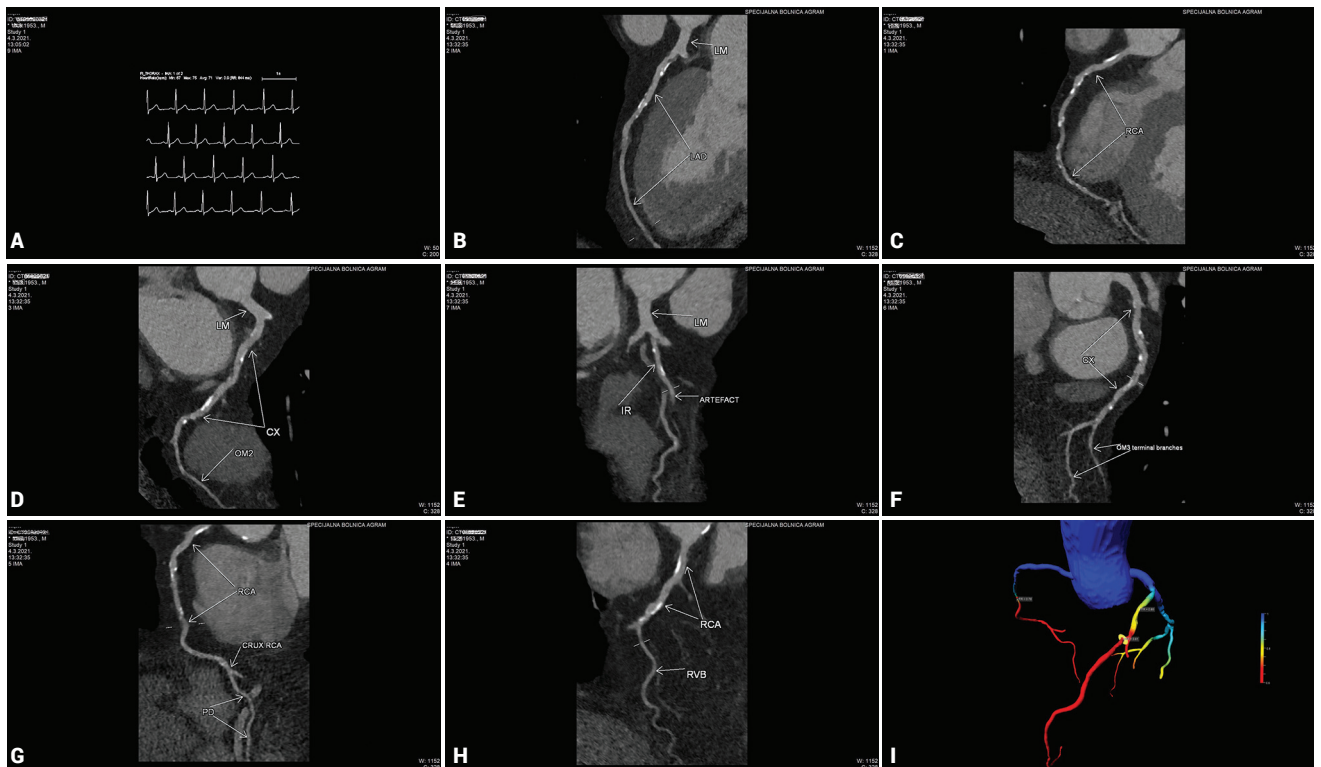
Male patient, 67 years old, with hypertension and obesity (body mass index 37.4 kg/m²; chest/waist circumference 129/122 cm). After intravenous application of four doses of metoprolol, heart frequency remained variable with average rate 71 bpm (A). Longer calcifications were found in proximal segments of the right coronary artery (RCA) and the left anterior descending artery (LAD), but despite the latter the image quality of three major epicardial vessels allowed accurate analysis (B, C, D). Despite minor motion artefacts in some segments, even terminal branches of major vessels are clearly visible (E, F, G, H). Computed tomography fractional flow reserve (CT-FFR) revealed hemodynamically significant stenosis of mid RCA (FFR=0.78) and LAD (FFR=0.80) (I).
